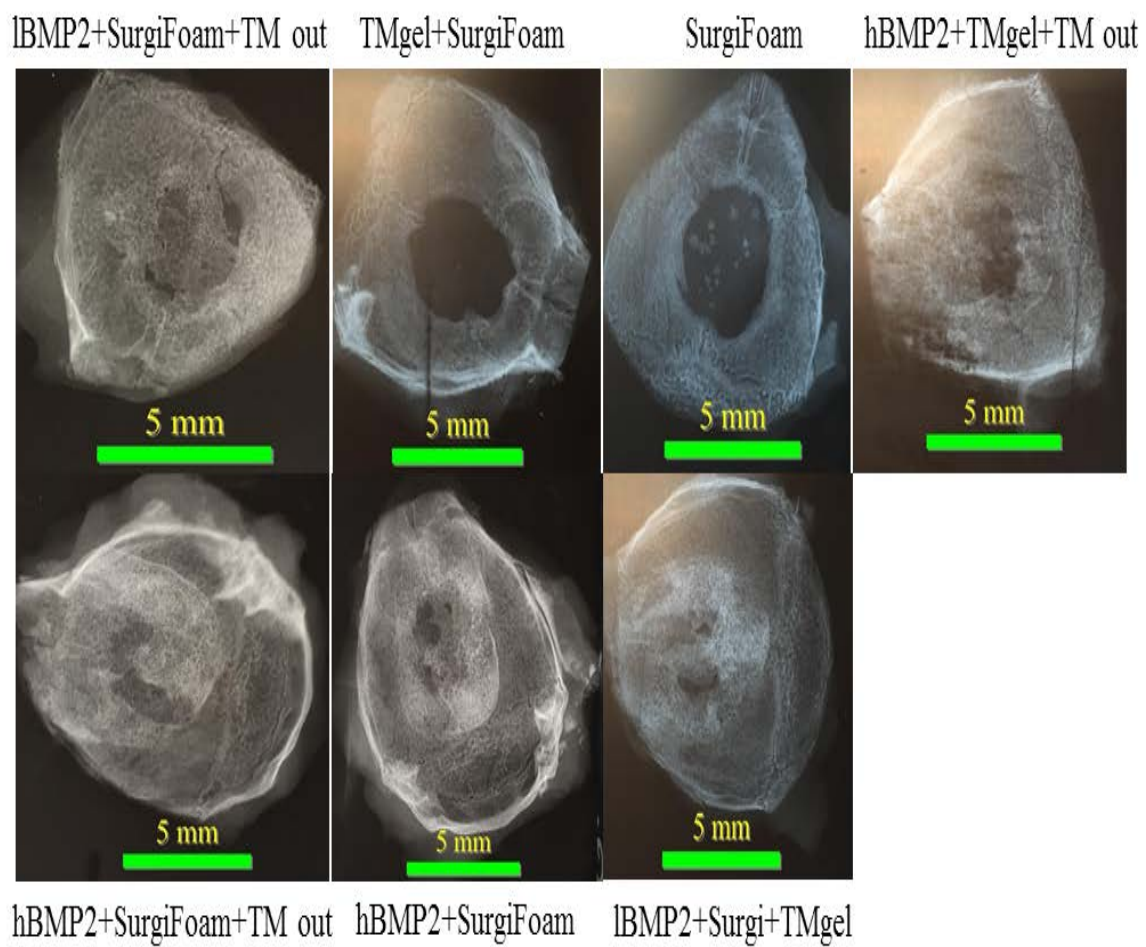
Representative radiographs.
